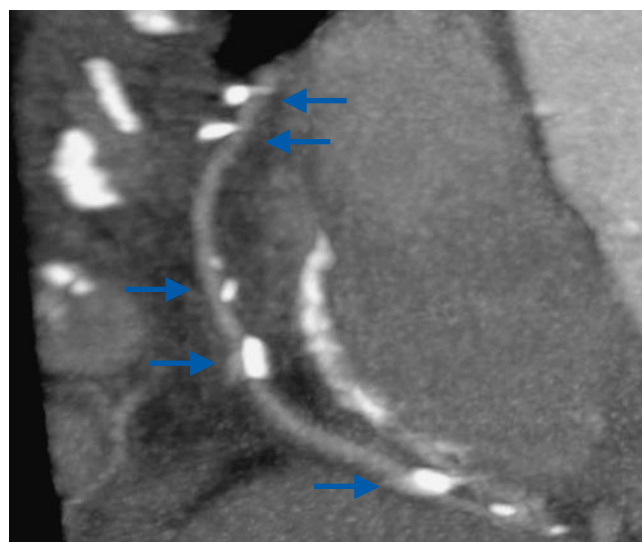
Surgical clip artifacts can limit cardiac CT evaluation of coronary bypass grafts significantly. Double oblique maximum-intensity projection image (10 mm thick) demonstrates multiple surgical clips placed along the length of a radial-to-PIV graft (*blue arrows*). Artifact from these metallic clips can partially or completely obscure the adjacent vessel lumen, precluding evaluation of these segments for the presence or absence of stenosis. Although CT can unequivocally demonstrate graft patency, surgical clip artifact usually does not allow complete graft evaluation to rule out graft stenosis.
